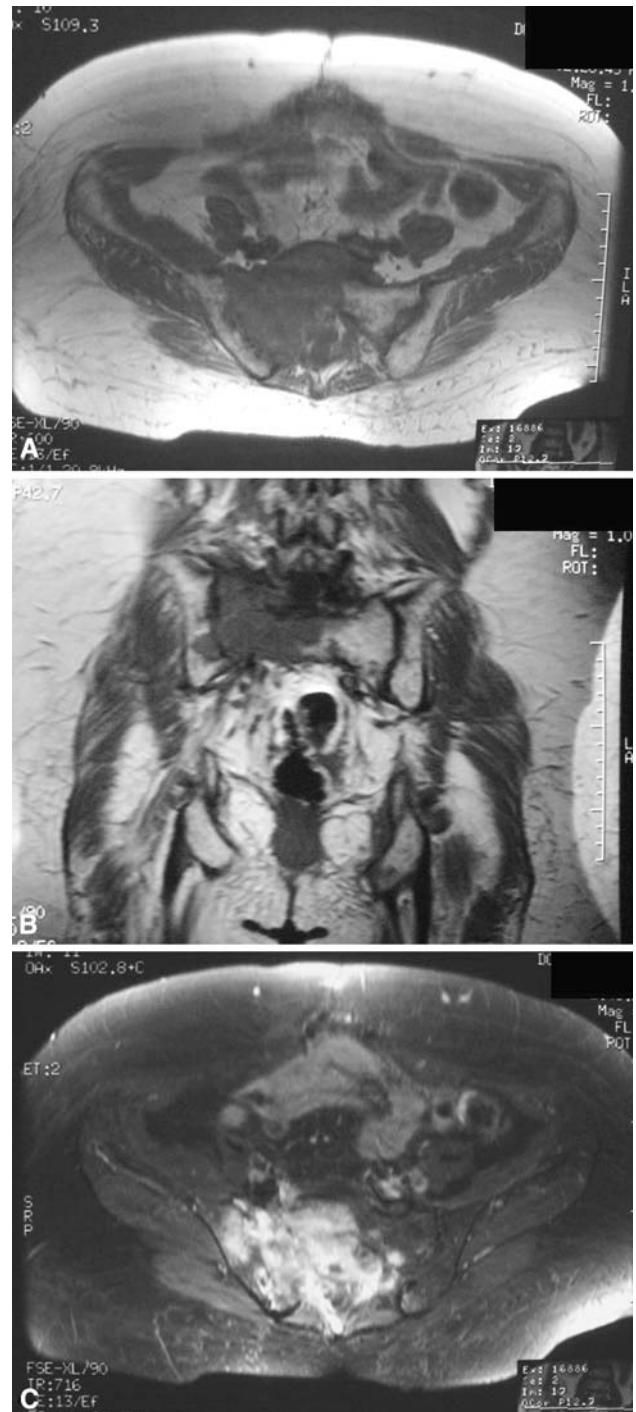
MRI shows a 8.3- × 6.8- × 3.5-cm diffuse abnormal marrow replacement in the sacrum, more on the right side, with a signal isointense to muscles on T1-weighted (A) axial (TR 600, TE 13) and (B) coronal (TR 750, TE 16.9) images. There is involvement of the sacroiliac joint, as well as the adjoining ilium, with foraminal effacement of the S1–3 nerve roots. (C) The lesion enhances heterogeneously with contrast.
